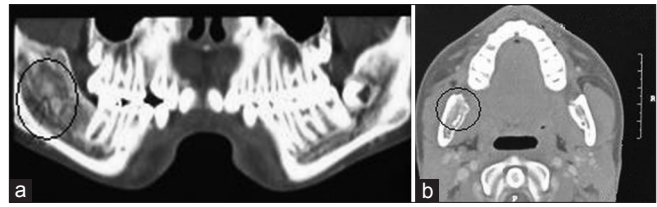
(a) Horizontal CT-scan, (b) coronal CT-scan
